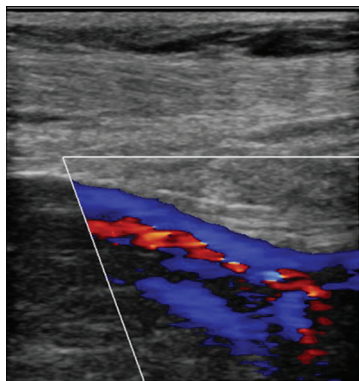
Doppler ultrasound showing an arteriovenous fistula in the right groin
